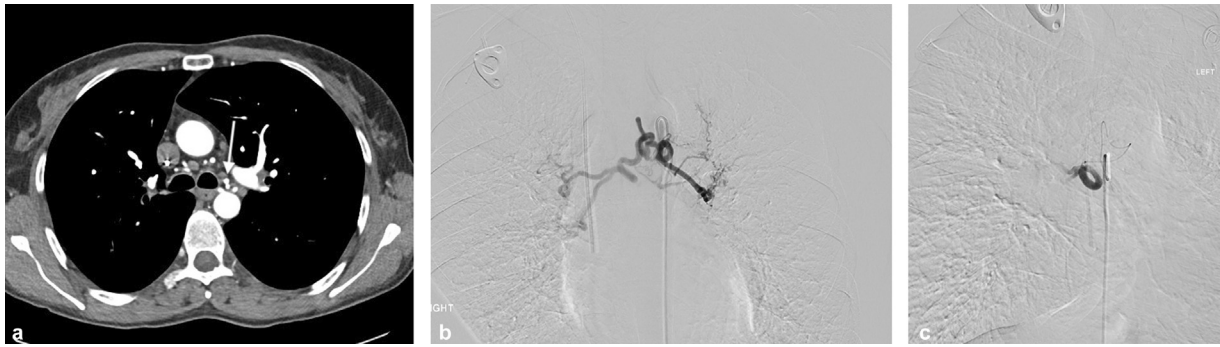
A 41-year-old woman with history of cystic fibrosis presenting with massive hemoptysis. (a) CT angiogram reveals enlarged, ectatic bronchial arteries with one origin from the ventral thoracic aorta at the level of the carina (arrow). (b) Selective angiogram demonstrates enlarged right and left bronchial arteries with a common origin from the aorta. (c) Selective angiogram of the right bronchial artery post-embolization shows pruning of the vasculature.
